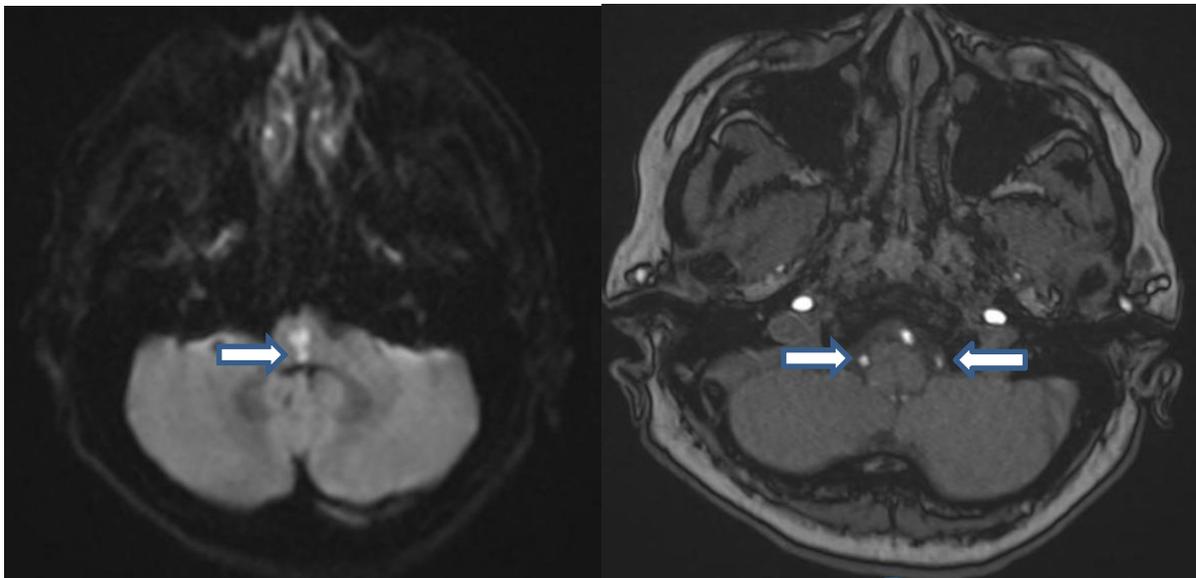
A key-like hyperintense lesion in the medial bilateral medulla (white arrow) can be seen on this DWI sequence on the left. On the right, both the vertebral arteries are visible and almost the same in caliber in this cut.
